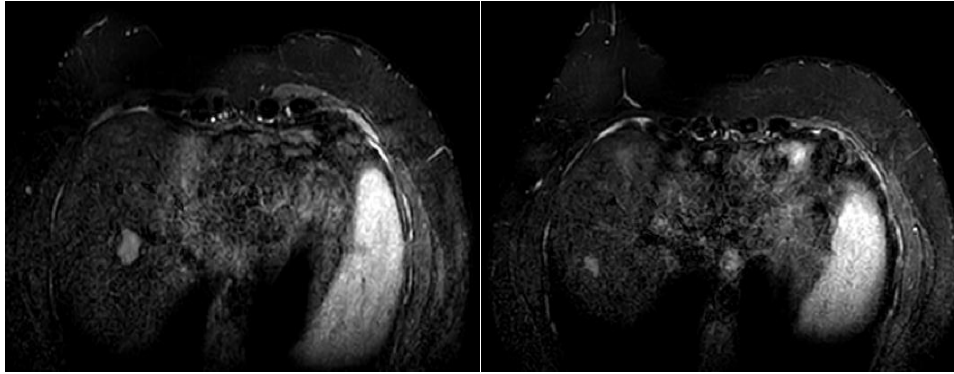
MRI breast study of 37 years old female patient with pathologically proven left breast infiltrative ductal carcinoma with metastatic left axillary lymph nodes. (BI-RADS-6) with axial sequences showed two hepatic focal lesions at the interface between subsegment VII and VIII measuring 1.4 cm and 2 cm.
